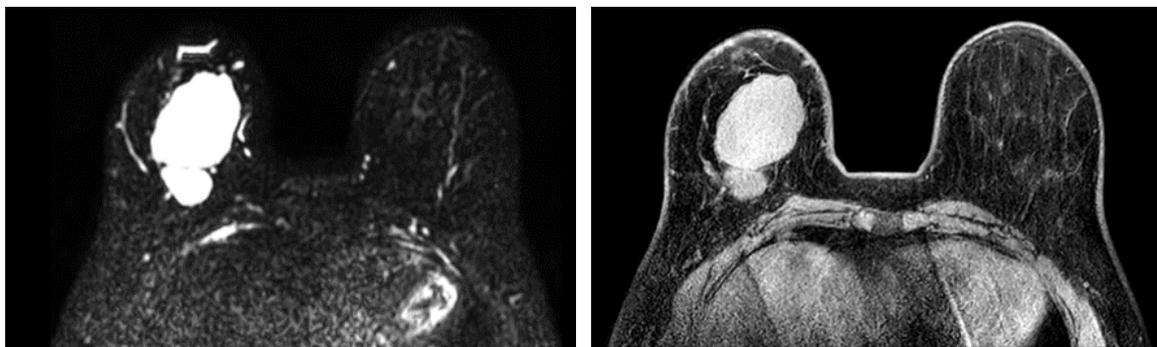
3T MRI image of breast sarcoma (DWI and postcontrast image) suggesting hyper enhancing lesions, with restricted diffusion.
